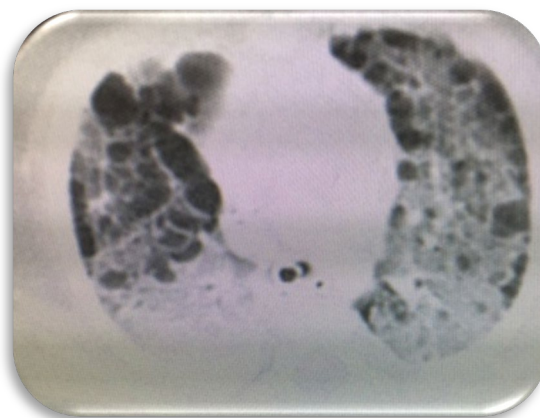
Axial chest CT with contrast show diffuse pulmonary cysts and nodules with intervening ground glass opacities.
